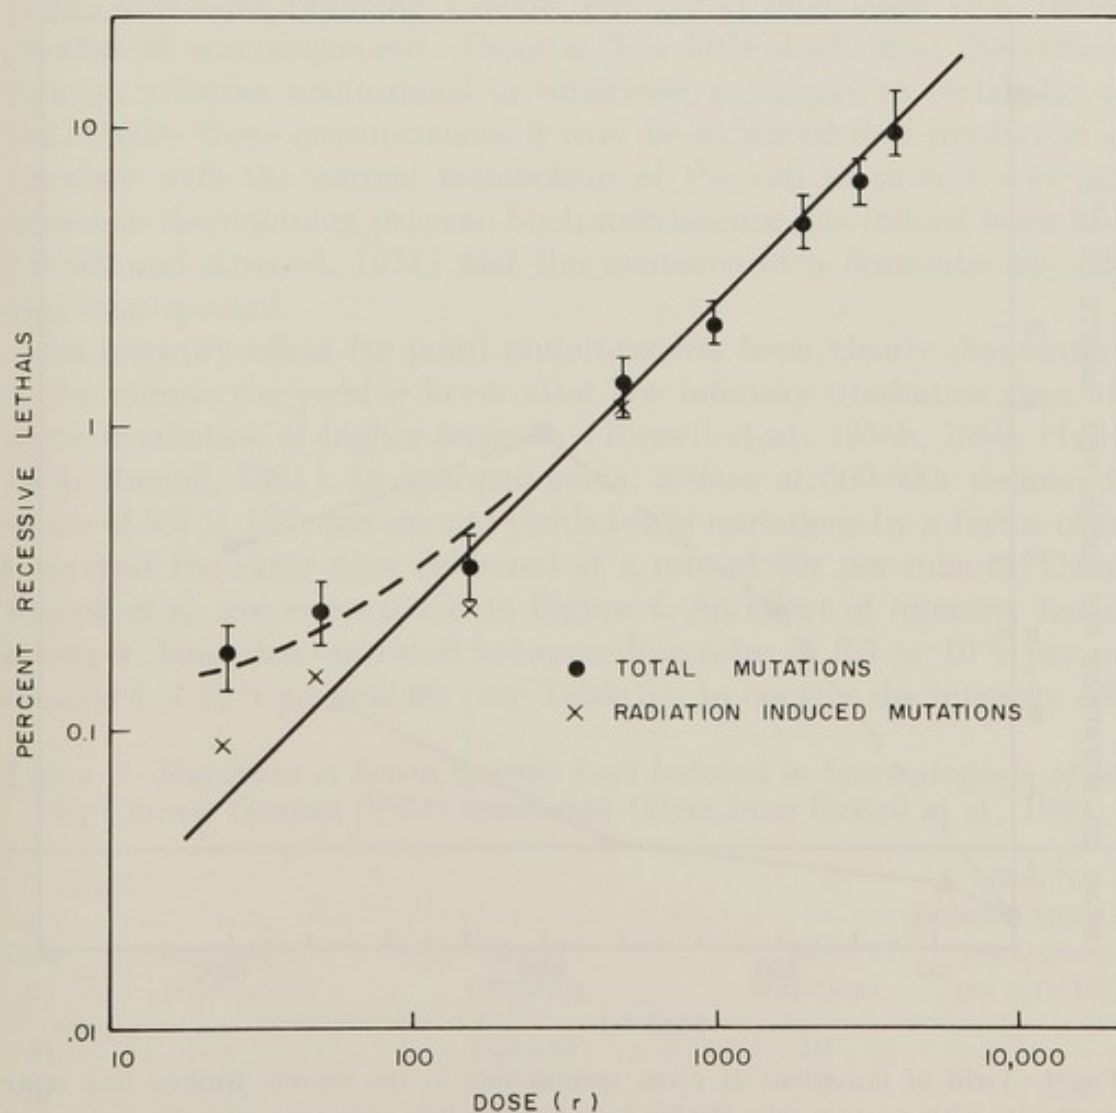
Yield of x-ray-induced mutations in *Drosophila* at low doses. The values for induced mutations were obtained by subtraction of control values from the values for spontaneous plus induced mutations (data from Spencer and Stern, 1948).
